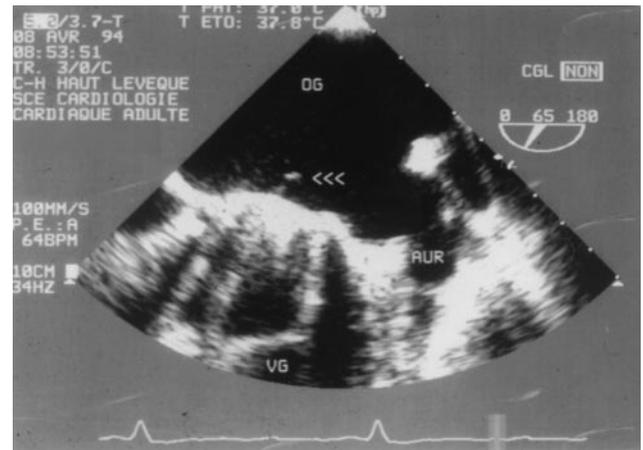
TEE view of a St. Jude medical mitral valve showing a strand on the atrial side of the prosthesis. TEE = transesophageal echocardiography.
